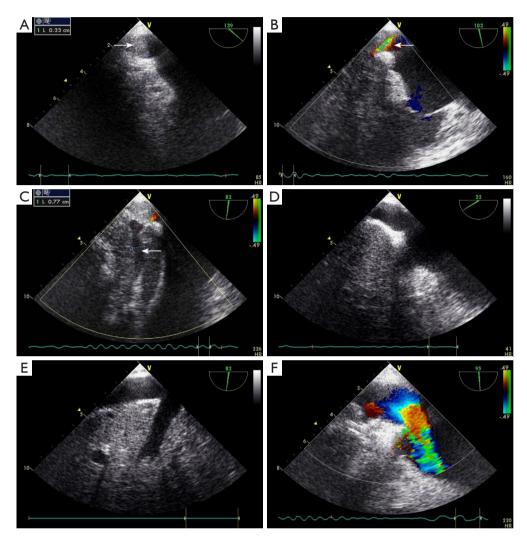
In the same patient as in Figure 2 (60-year-old male), intraoperative TEE showed the status of the tumor thrombus in the inferior vena cava and was used for immediate postoperative evaluation of the complete removal of the tumor thrombus from the inferior vena cava and its tributaries. (A) Preoperative TEE showed an irregular, slightly hyperechoic tumor thrombus (arrow) in the inferior vena cava that was attached to the vessel wall. (B) The blood flow appeared to accelerate suddenly as it passed through the narrow segment between the thrombus and the vessel wall, displaying a colorful turbulent flow signal (arrow). (C) Hepatic venous flow stasis with a dilated internal diameter (arrow). (D,E) A comprehensive postoperative multiangle scan showed no significant tumor thrombus echo in the inferior vena cava and hepatic veins. (F) Postoperative TEE showed good blood flow filling in the inferior vena cava. TEE, transesophageal echocardiography.
